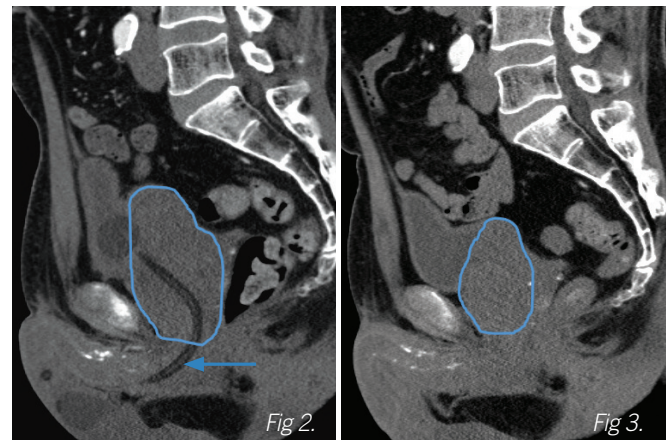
Sagittal CT image one week prior to PAE demonstrates an enlarged prostate (outlined in blue) with a prostate volume of 150 cc. The patient was unable to urinate due to severe BPH, and was living with an indwelling Foley catheter (arrow).
